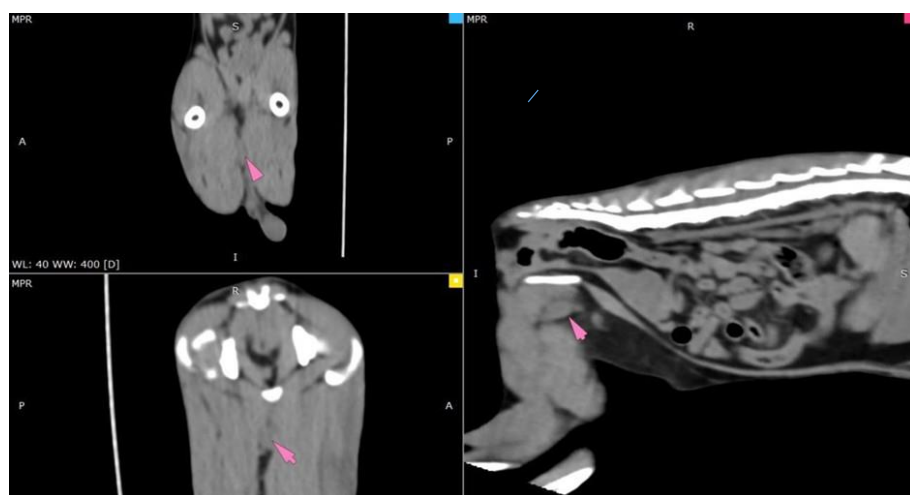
Computed tomography (CT): unilateral right-sided inguinal cryptorchidism. The CT scan was performed in three standard planes: sagittal, dorsal, and transverse. The image on the right represents the sagittal plane, the upper left image represents the dorsal plane, and the lower left image represents the transverse plane. The pink arrowhead indicates the undescended testis.
